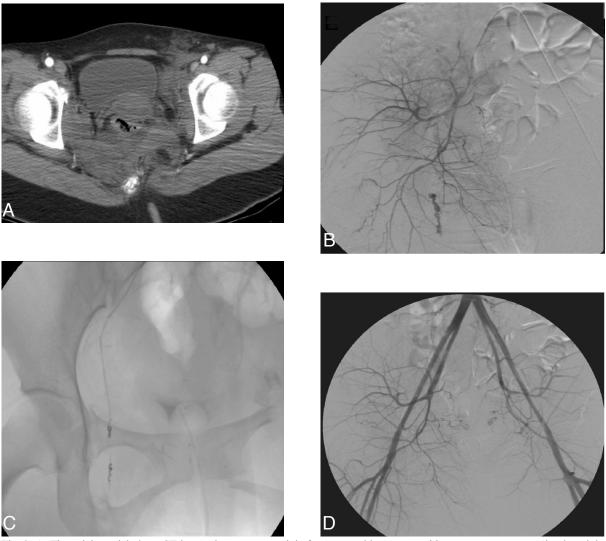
A: The axial arterial phase CT image demonstrates pelvic fractures and hematoma without contrast extravasation in pelvic cavity. B: Conventional angiogram demonstrates continuous active hemorrhage from a branch of the right internal iliac artery. C: It was subsequently embolized by two coils and Geofoam. D: Post-embolization angiogram shows no evidence of contrast extravasation.
